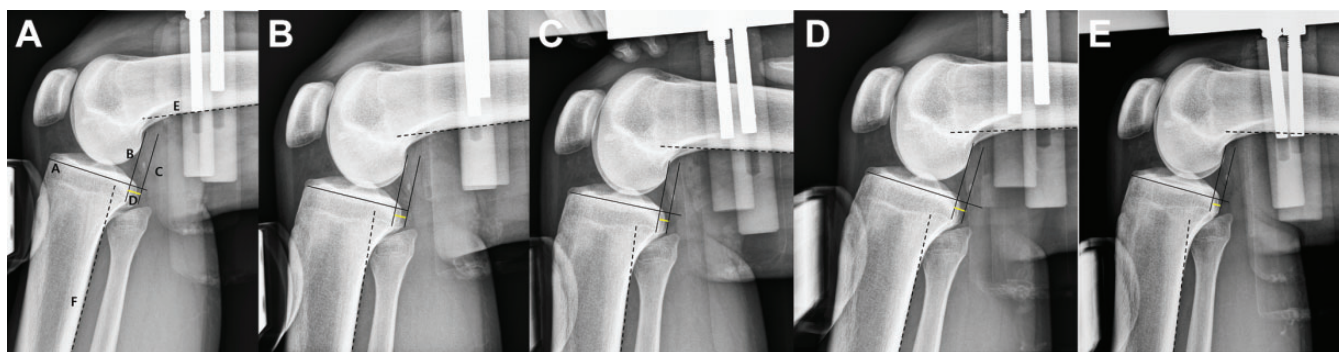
A representative case of a 24-year-old man with a posterior cruciate ligament injury. The noninjured left knee had undergone repeated radiographic examinations to compare side-to-side difference during nonoperative management. (A) The first examination, at a knee flexion angle (KFA, the angle between the extension line of the dashed black lines of 73.3°), resulted in a posterior tibial displacement (PTD, yellow line) measurement of 6.58 mm. (B) KFA of 76.8° and PTD of 4.9 mm. (C) KFA of 90.7° and PTD of 3.98 mm. (D) KFA of 79.5° and PTD of 5.48 mm. (E) KFA of 88.5° and PTD of 4.37 mm.
